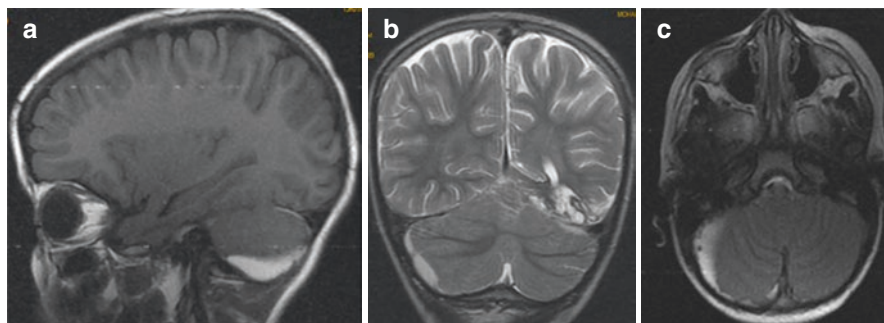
Brain MRI on sagittal non-contrast T1 (a), coronal T2 (b) and perfusion axial sequence (c) demonstrating a posterior fossa CSDH over the right cerebellar hemisphere
